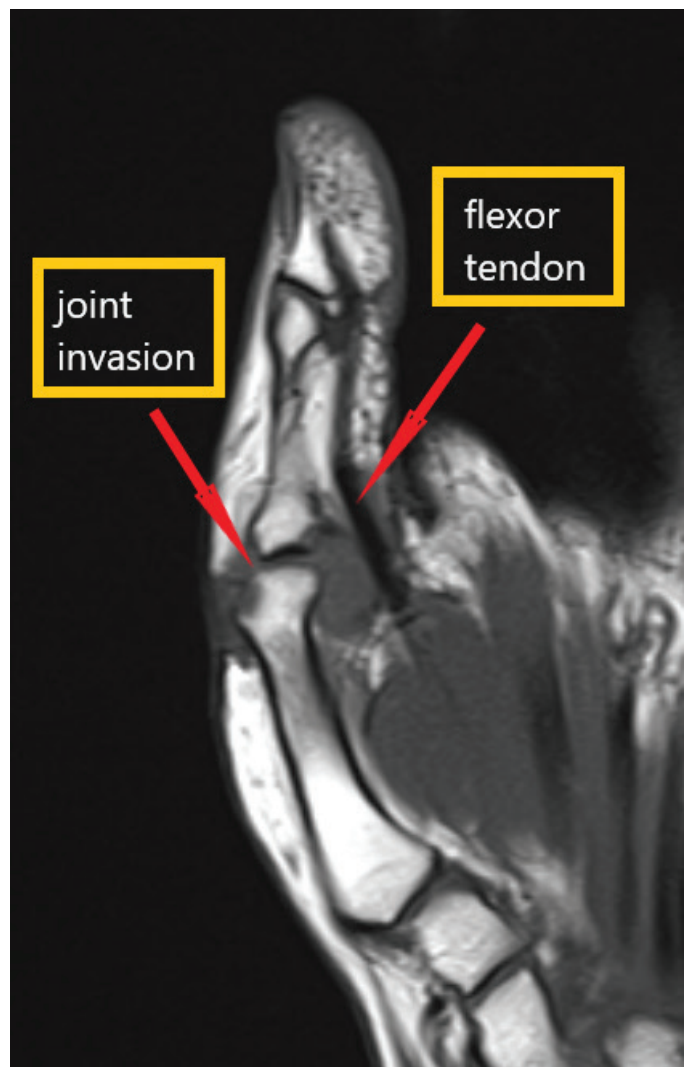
Joint invasion. Magnetic resonance images of thumb metacarpophalangeal joint
